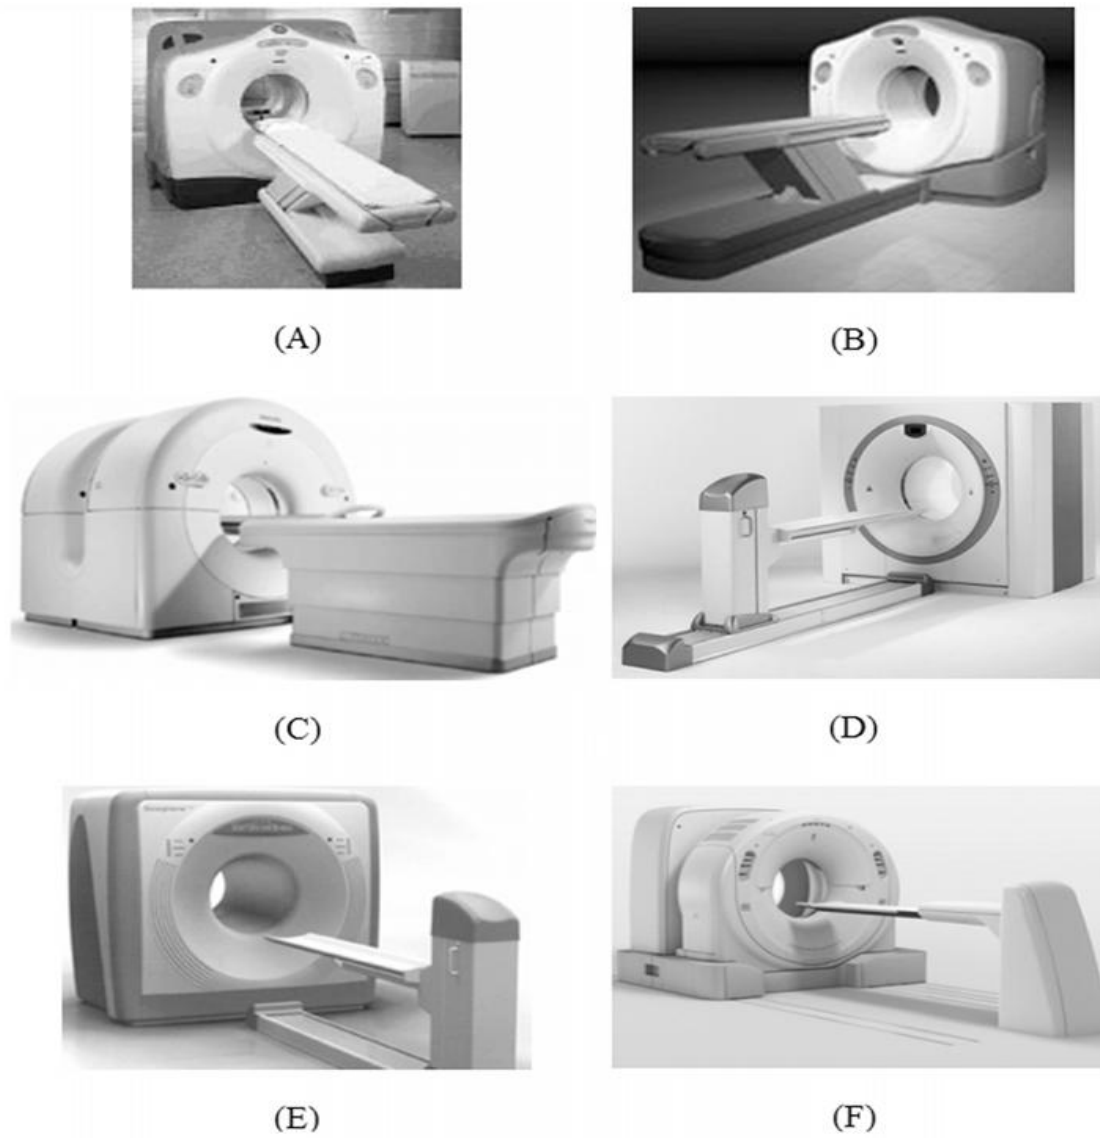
Some of the most popular commercial PET/CT systems. (A) – Discovery LS (GE Healthcare), (B) - Discovery ST (GE Healthcare), (C) – Gemini (Philips Healthcare), (D) – Biograph (Siemens Healthcare), (E) – Septre P3 (Hitachi Medical Systems), (F) – Aquiduo (Toshiba Medical Corporation) (taken from [8])
